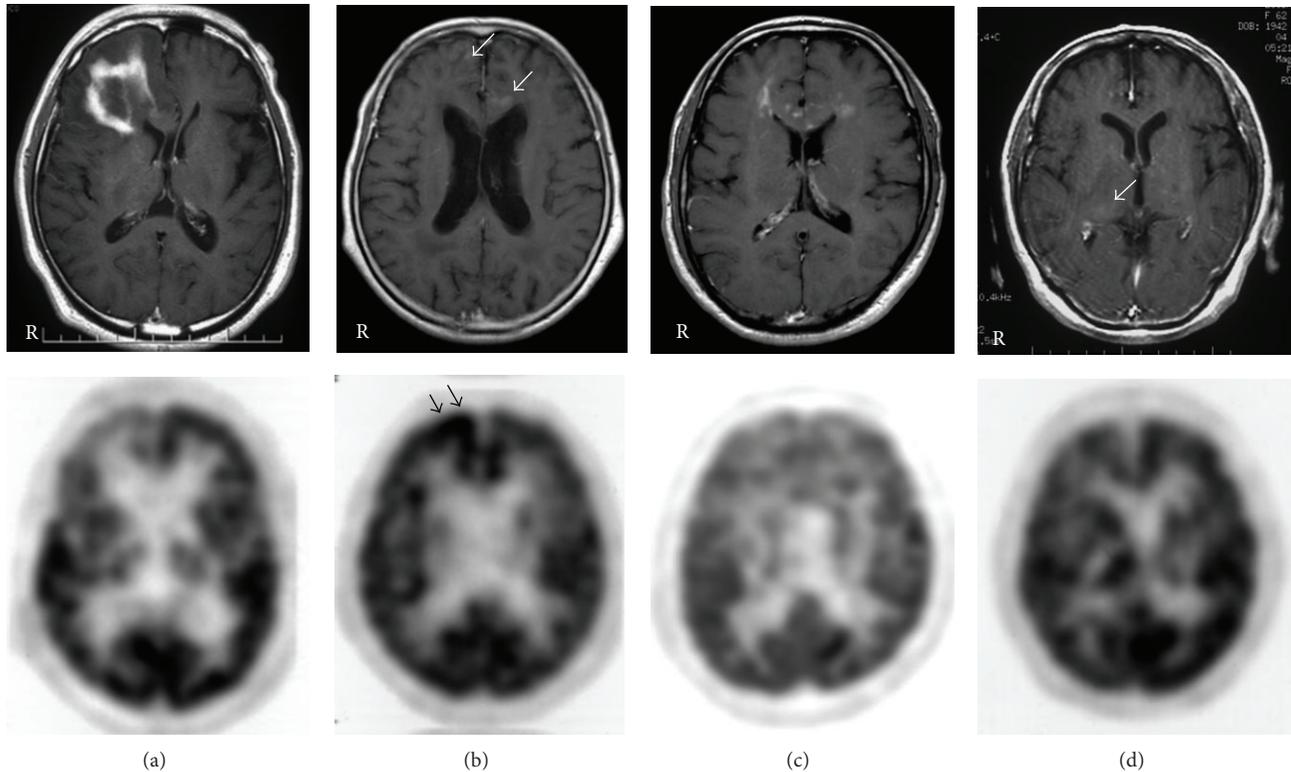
Contrast-enhanced T1-weighted MR (upper) and  $^{18}\text{F}$ -FDG PET (lower) images in PCNSL patients with atypical MR findings. MR images show a ring-like enhanced lesion in the right frontal lobe (a), multiple faint enhanced lesions in the right cerebral cortex and the corpus callosum (b), multiple small enhanced lesions in the bilateral frontal white matter and the corpus callosum (c), and no enhancing lesion in the brain (d). PET images show no  $^{18}\text{F}$ -FDG uptake in the lesions except for moderate  $^{18}\text{F}$ -FDG uptake in the right frontal cortex (arrow) in case (b).
